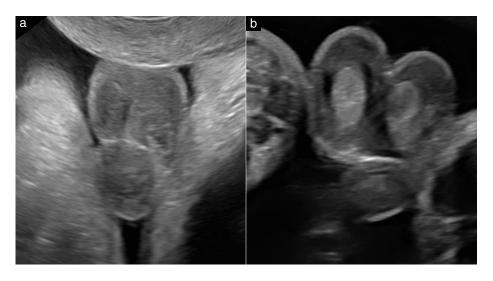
Subtle signs of congenital hypotonia on ultrasound imaging: undescended testes. (a) Undescended testes in nemaline myopathy at 35 weeks' gestation, with (b) normally descended testes at 31 weeks for comparison.
